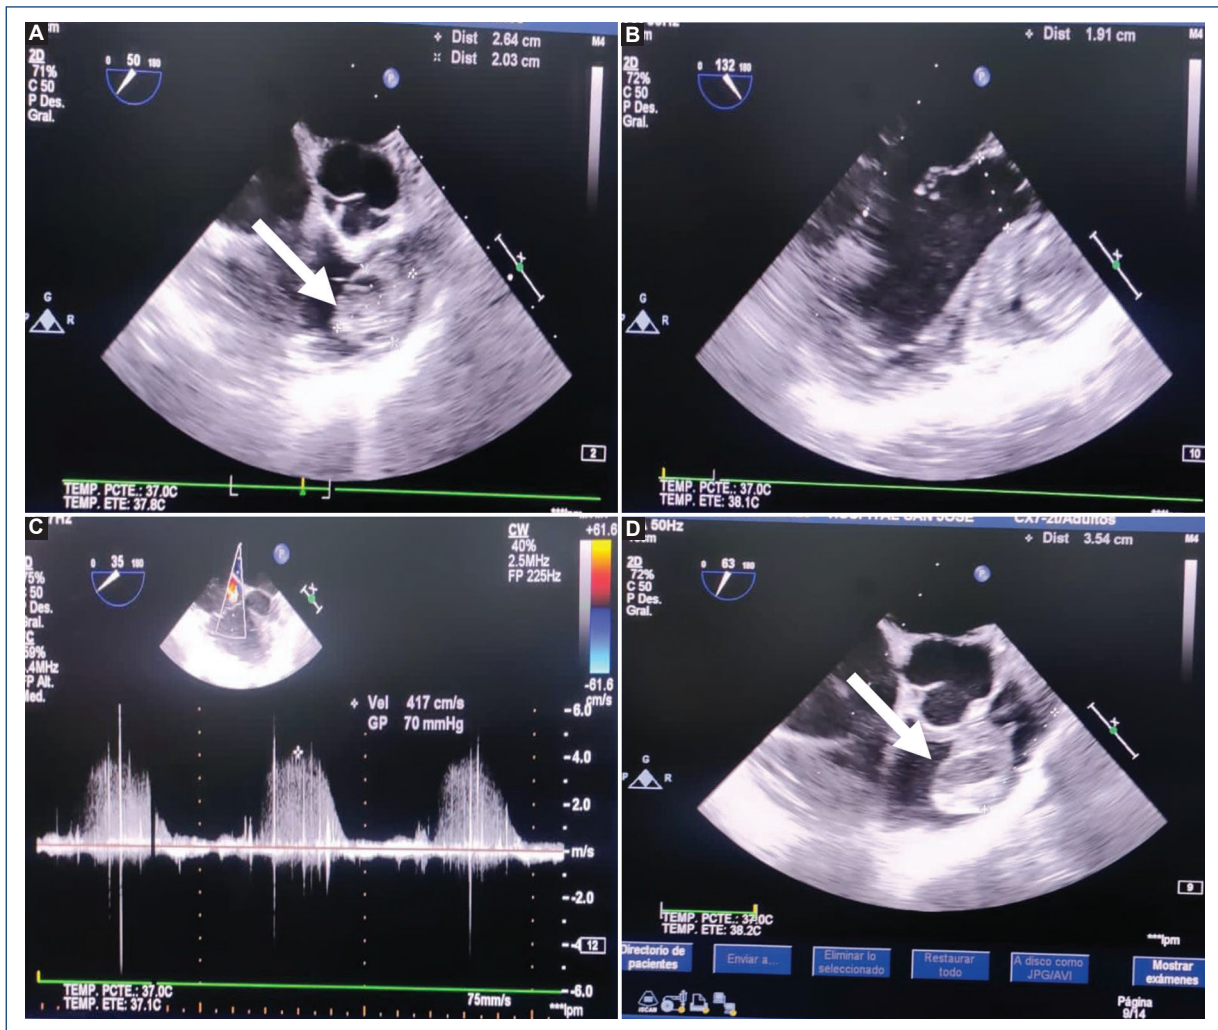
A-D: echocardiogram. Echocardiogram was performed showing an image of a cardiac mass with regular borders, high mobility toward the pulmonary valvular plane, circular in appearance (2.9 × 2.2 cm), with areas of echolucencies in its interior located (probable myxoma) in the right ventricular outflow tract causing functional pulmonary stenosis and severe right ventricle dilatation.
